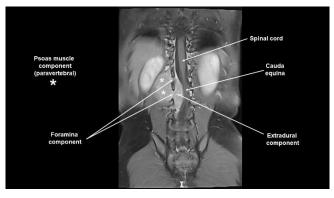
Spine MRI in axial plane, T1, gadolinium contrasted, exhibiting the NB and its paravertebral, extradural and foraminal components, resulting in swelling of psoas muscle and lateral displacement of the right kidney. Personal archive of Dr. Marcius Benigno Marques dos Santos, MD.
